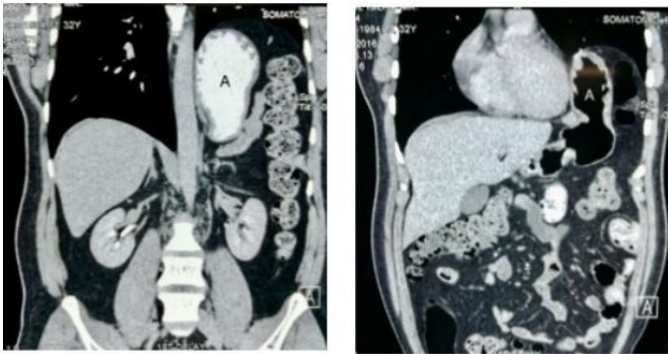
Contrast CT scan, coronal view showing displacement of the stomach (A) in to the left mediastinum.
